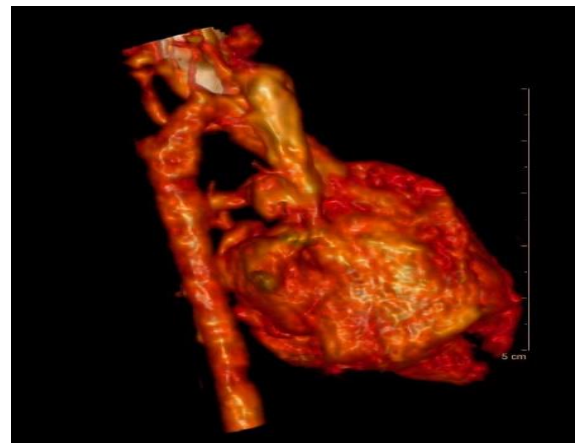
CT angiogram of double sided aortic arch compressing trachea.
